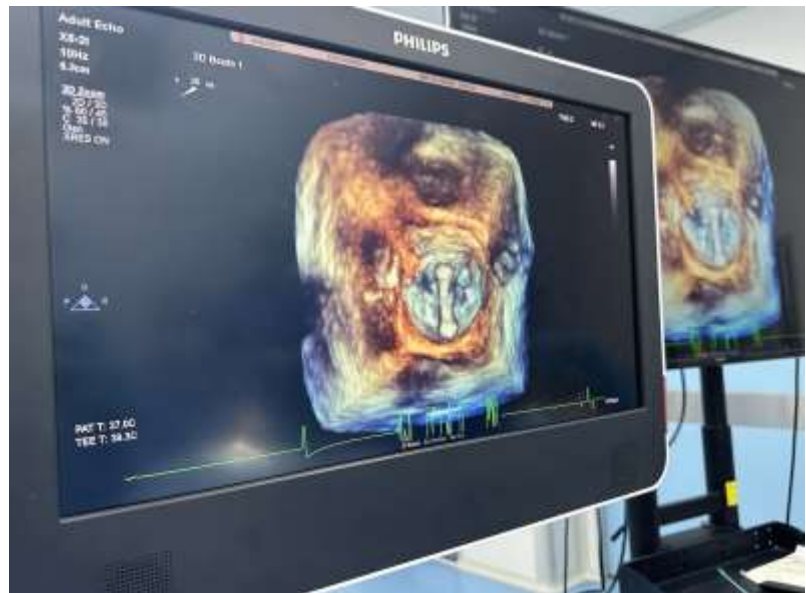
Image above is a 3D ultrasonographic view of the mitral valve with V-clamp in position.
